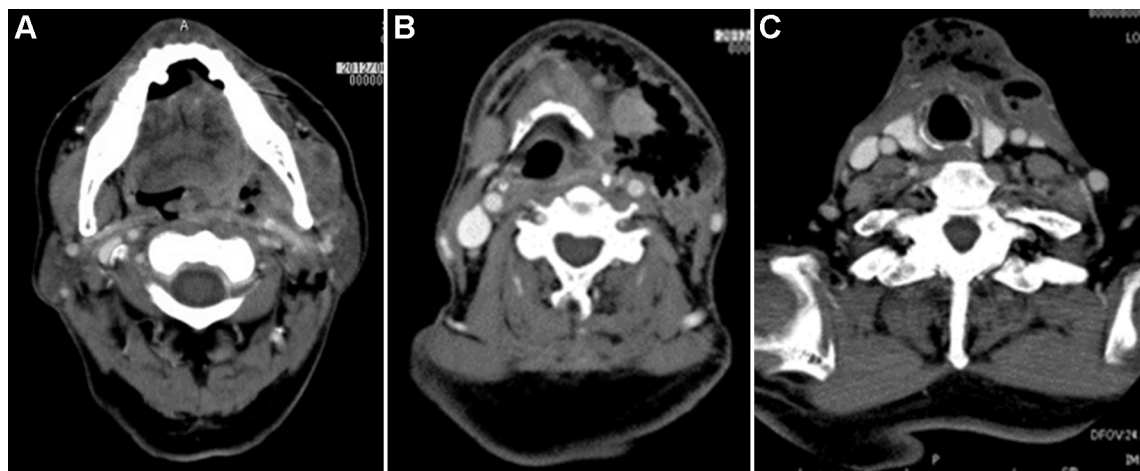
Initial CT findings at our hospital. (A) Abscess in the left parapharyngeal space. (B) Abscess in the left submandibular space. (C) The abscess extends to the level of the thyroid gland in the anterior cervical region.
